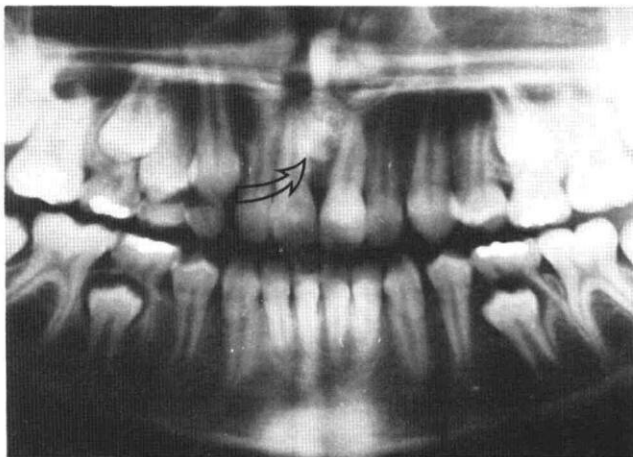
Panoramic radiograph of the patient at age 12 years showing a radiopaque tooth-like structure between the roots of the central incisors.
